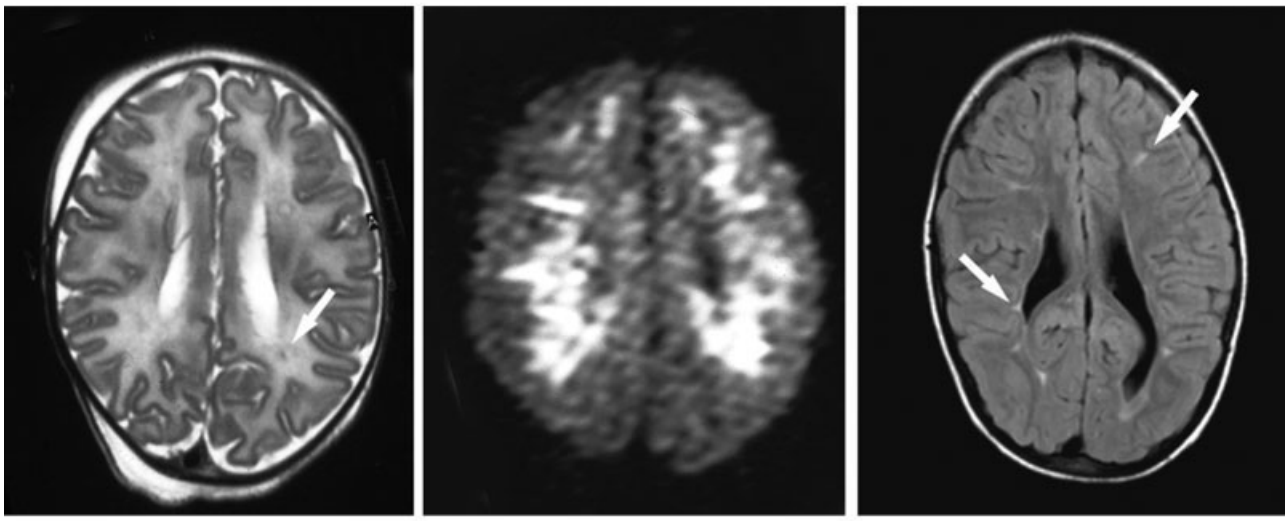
Magnetic resonance imaging (MRI) T2-weighted spin-echo sequences (left) and diffusion-weighted imaging (middle) 5 days after the onset of human parechovirus (HPeV) infection and fluid-attenuated inversion recovery sequence (right) at 7 years of age (Patient 2). Note diffuse increase in high signal intensity in the white matter mixed with several low signal intensity punctate lesions (arrow) (left), diffuse high signal intensity in the periventricular white matter on diffusion-weighted imaging (DWI) (middle), and mild ventricular dilatation and punctate periventricular gliosis in the periventricular white matter (arrows) (right).
